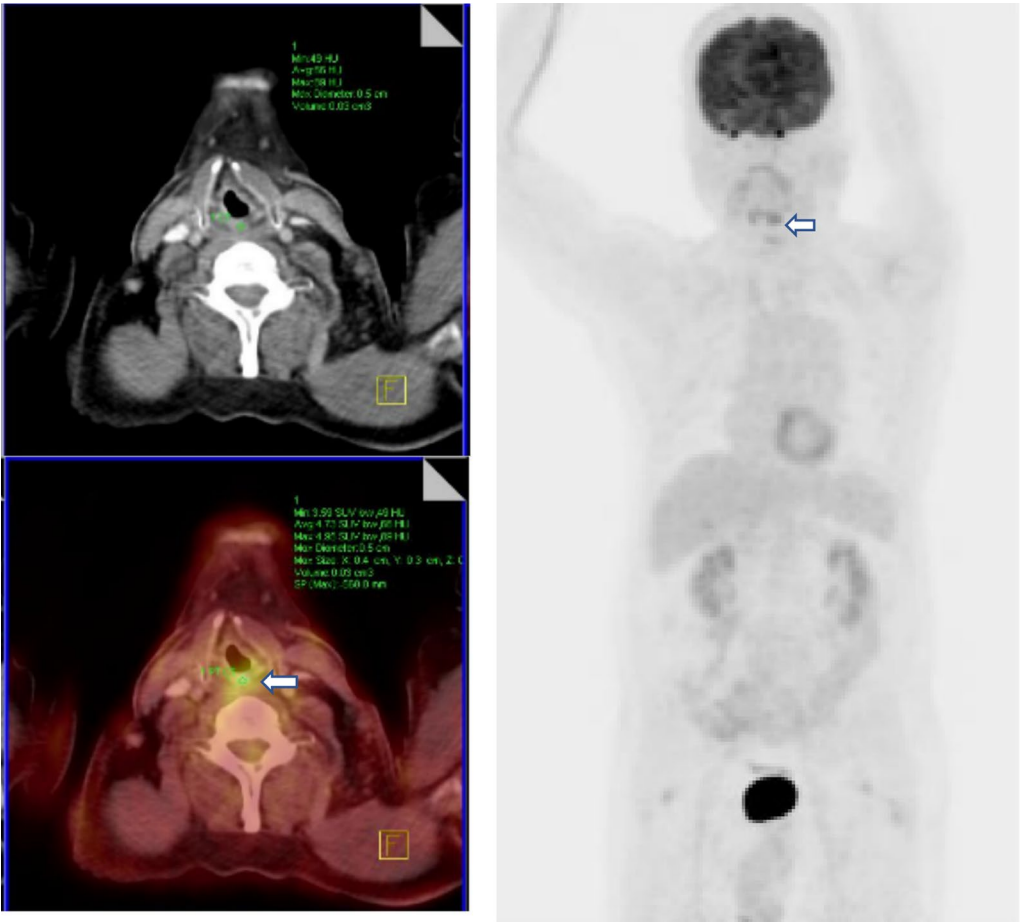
Axial PET/CT: focal intense FDG uptake in a hypodense posterior left vocal cord (arrow) mass with adjacent fat-plane infiltration, consistent with primary laryngeal carcinoma (Warburg effect). Courtesy: centre for diagnostic nuclear imaging
